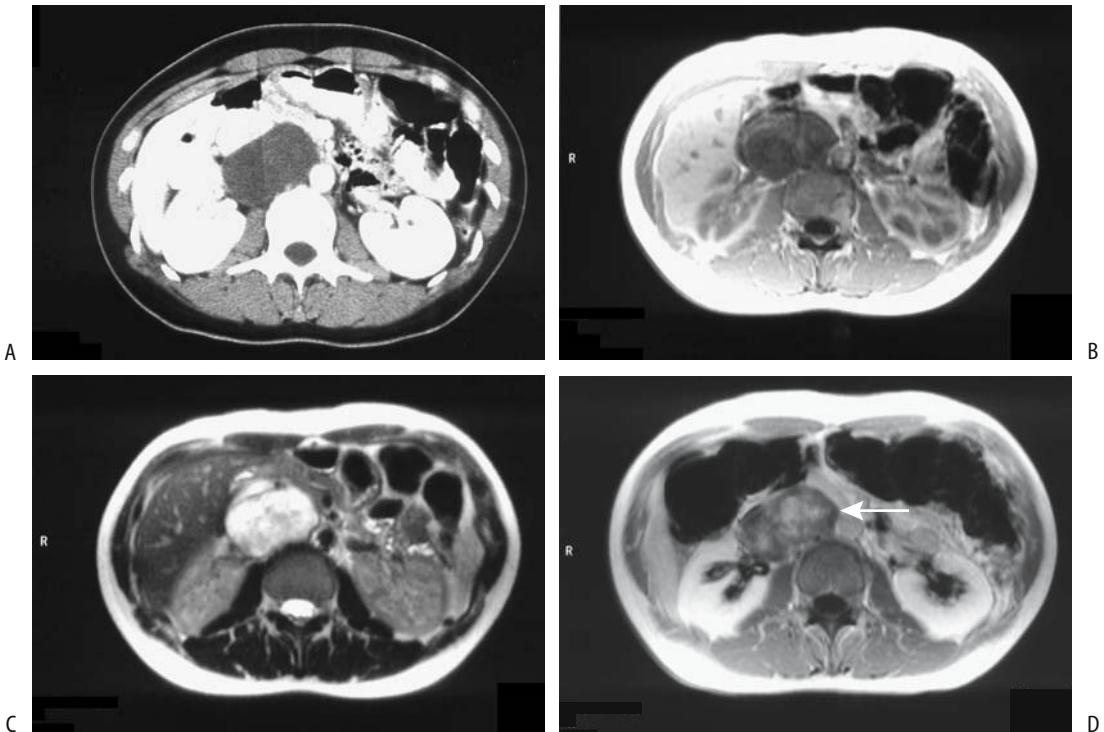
Neurilemoma. A: Contrast-enhanced CT identifies a hypodense tumor in right adrenal region, suggestive of a cyst. B: T1-weighted MR image reveals a homogeneous hypointense tumor. C: Turbo spin echo T2-weighted image the hyperintense tumor is located posterior to the inferior vena cava. D: Contrast-enhanced T1-weighted image shows inhomogeneous contrast enhancement (arrow). (Source: Rha SE, Byun JY, Jung SE, Chun HJ, Lee HG, Lee JM. Neurogenic tumors in the abdomen: tumor types and imaging characteristics. *Radiographics* 2003;23:29–43, with permission from the Radiological Society of North America.)
